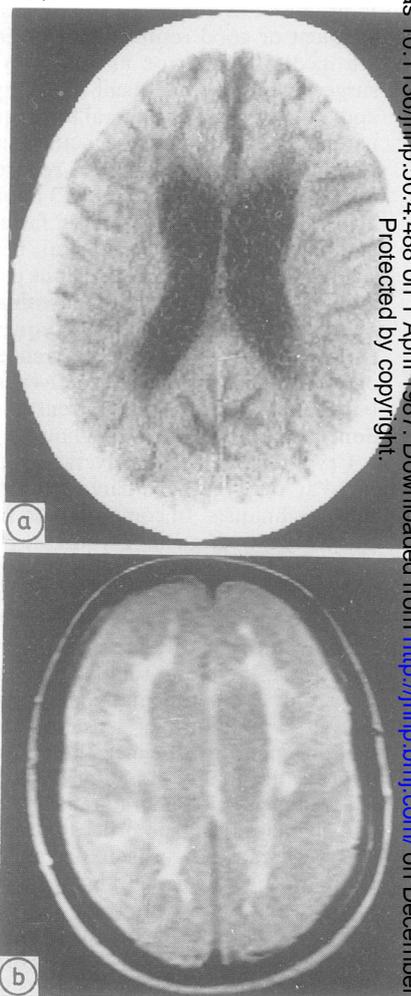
Fig CT scan and MR scan of patient (CT above, MR below). See text.
